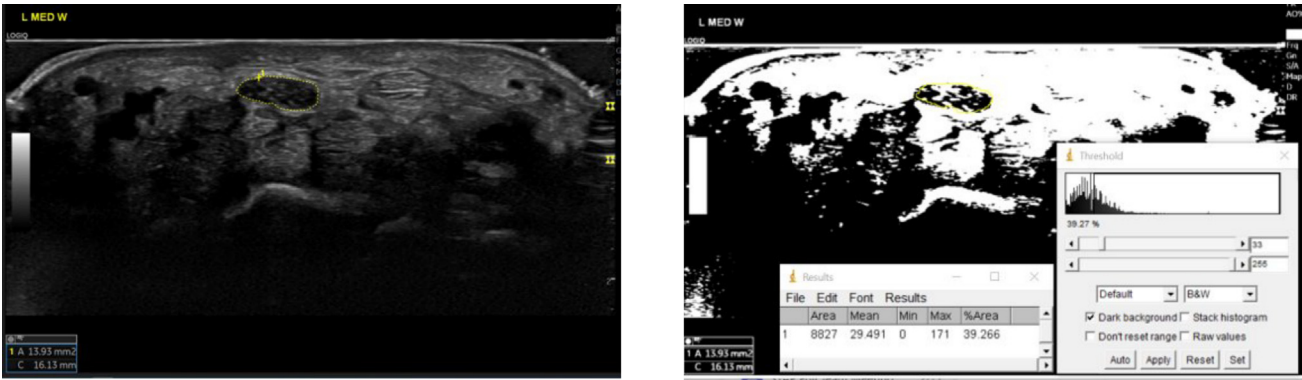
Black-White fraction method. Left: Sonographic image of left median nerve at wrist. Right: Image conversion in Image J software for black-white fraction method.
